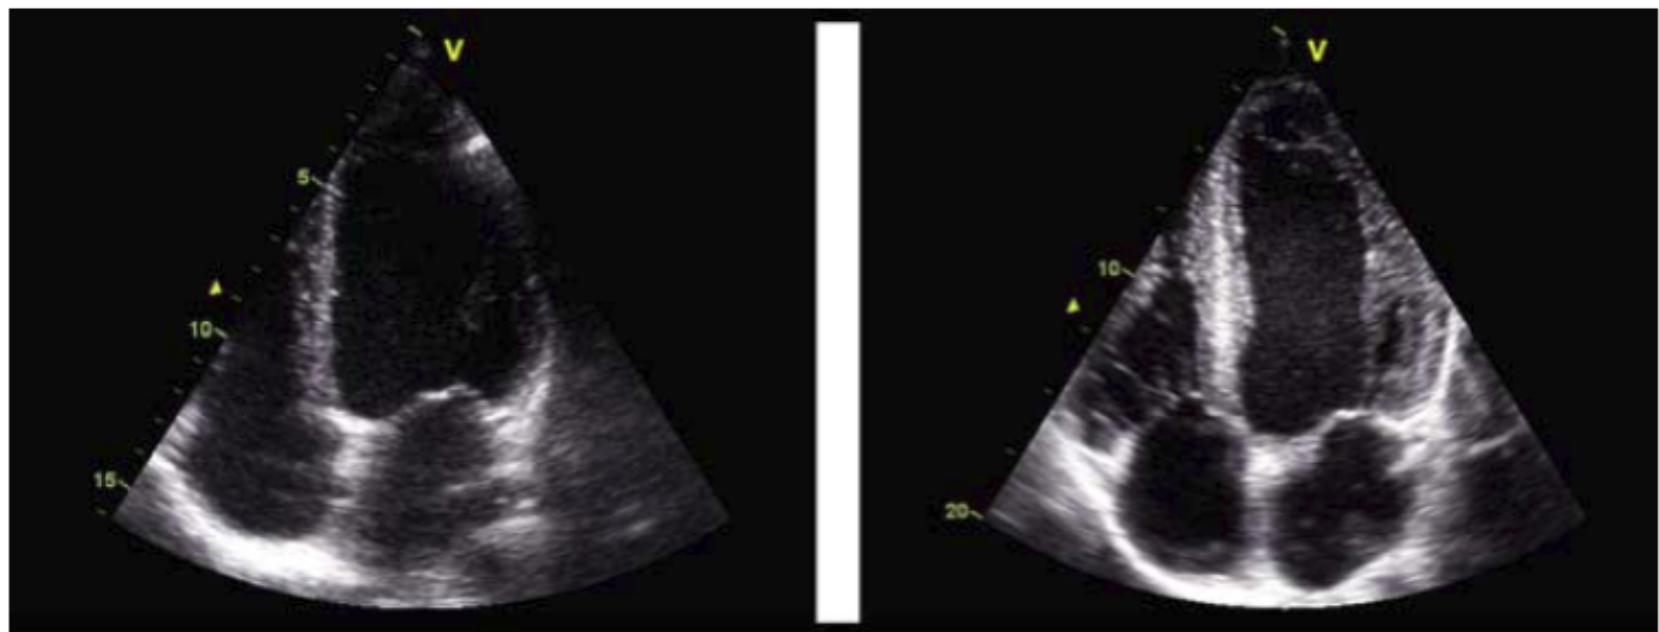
Echocardiographic image of a drug-free 25-year-old powerlifter (*left*) with normal left ventricular wall thickness and of an AAS-using 37-year-old bodybuilder (*right*) with concentric left ventricular hypertrophy
